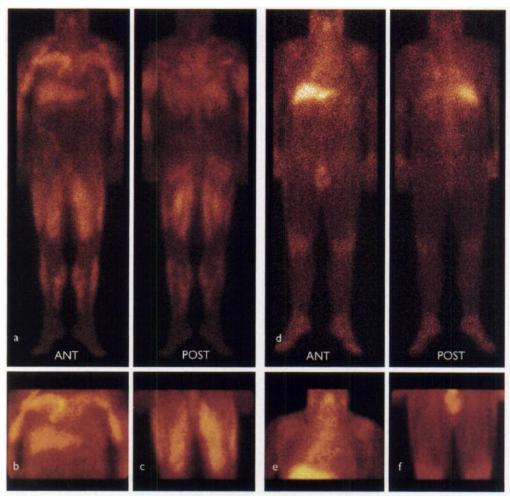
Gallium-67 scintigraphy of 65-yr-old man, nonsmoker, with severe sarcoidosis. (a-c) After discontinuation of first course of prednisone treatment, abnormal, increased uptake of <sup>67</sup>Ga was observed in major pectoral muscles, both biceps muscles and muscles of the thighs, shins and calves. (d-f) After second course of prednisone treatment, normal distribution of <sup>67</sup>Ga in muscles is seen compared with earlier observations (a-c). Abnormal uptake was observed only in mediastinal lymph nodes and right lung.
